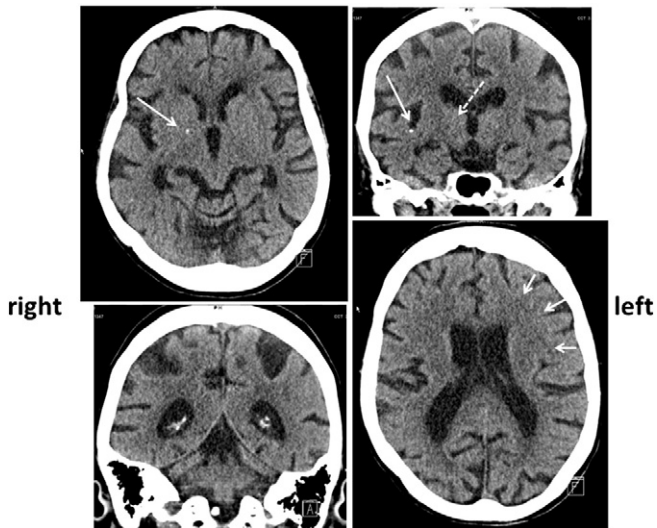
CT-scan of the brain showing diffuse atrophy (upper left, lower left), slight demyelination periventricularly (arrows, lower right), small lacunas in the basal ganglia (dashed arrow, upper right), and small calcifications of the basal ganglia and the temporal lobe on the right side (arrows, upper left and upper right).
